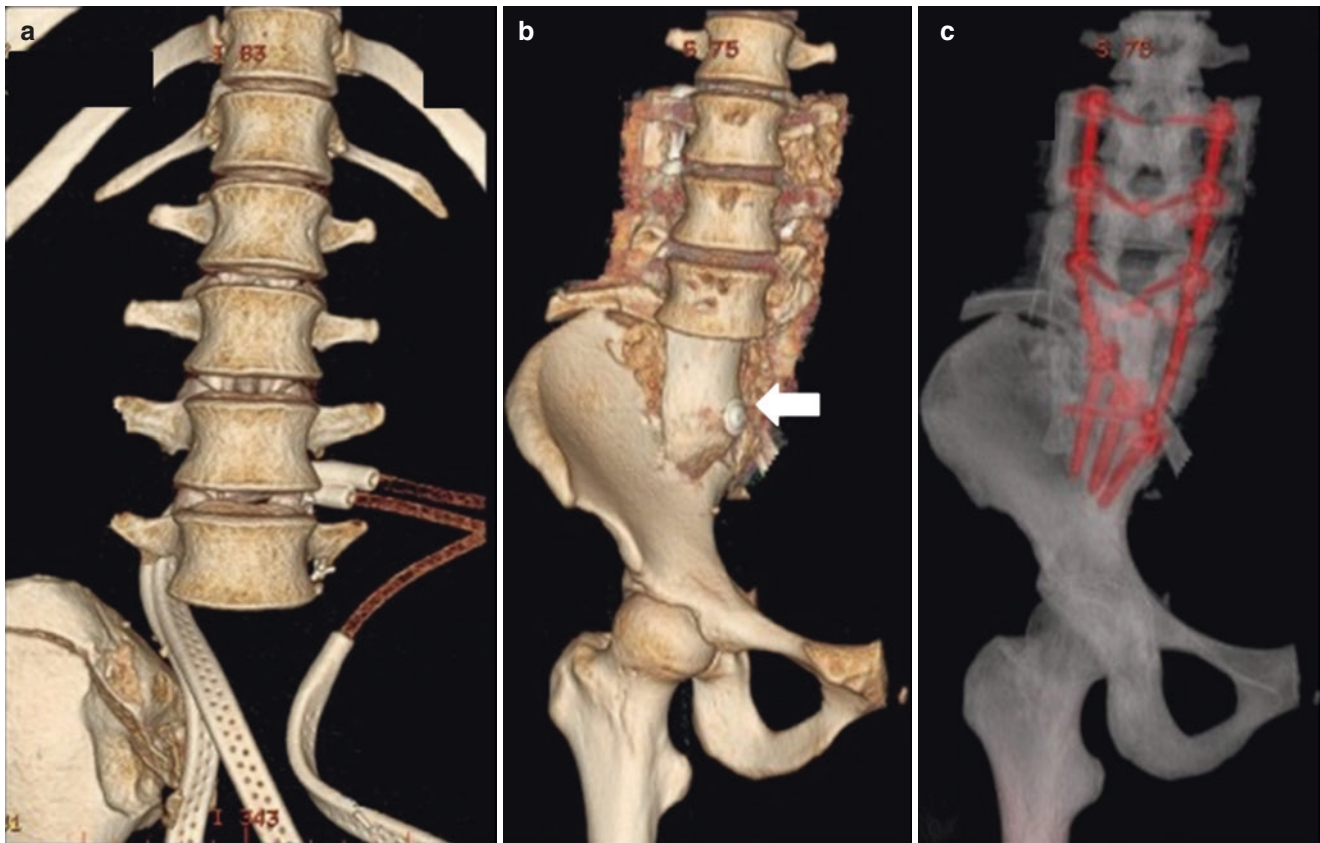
Following a total sacrectomy and hemipelvectomy (Mayo Type 4), the reconstruction is staged and CT scan is obtained to plan for an osteotomy of the amputated proximal femur to provide autogenous bone graft (a). The proximal femur (b—arrow) is then used to restore
